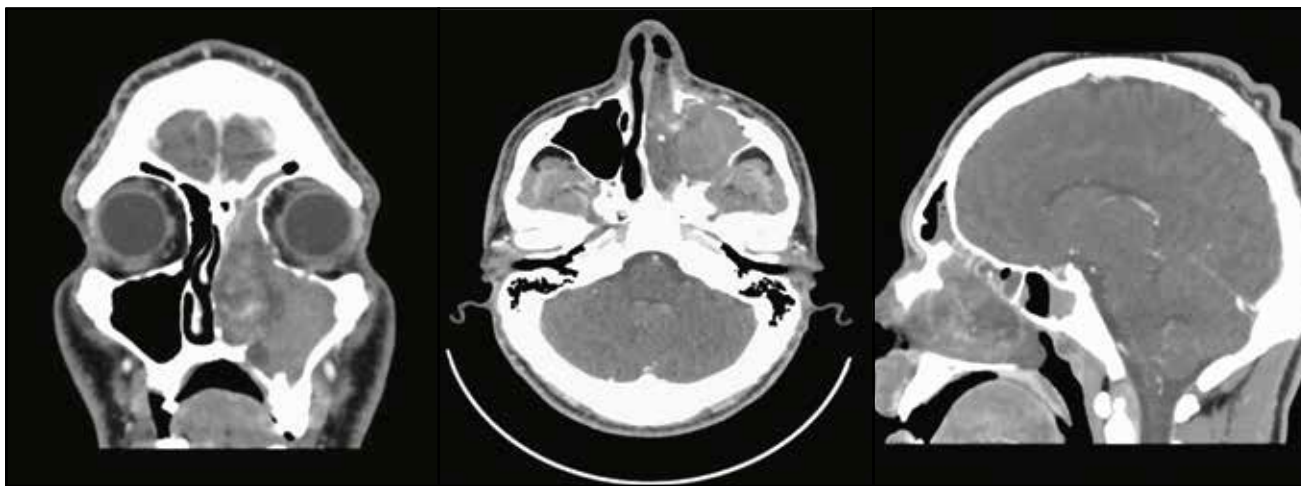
Preoperative imaging – Contrast-enhanced cranio-facial CT scan (coronal, axial and sagittal sections) reveals a macronodular heterogenous tissue lesion, partially hyperdense spontaneously, iodophilic, with multiple vascular trajectories apparently of the arterial type, localized in the left maxillary sinus and ipsilateral nasal cavity.
